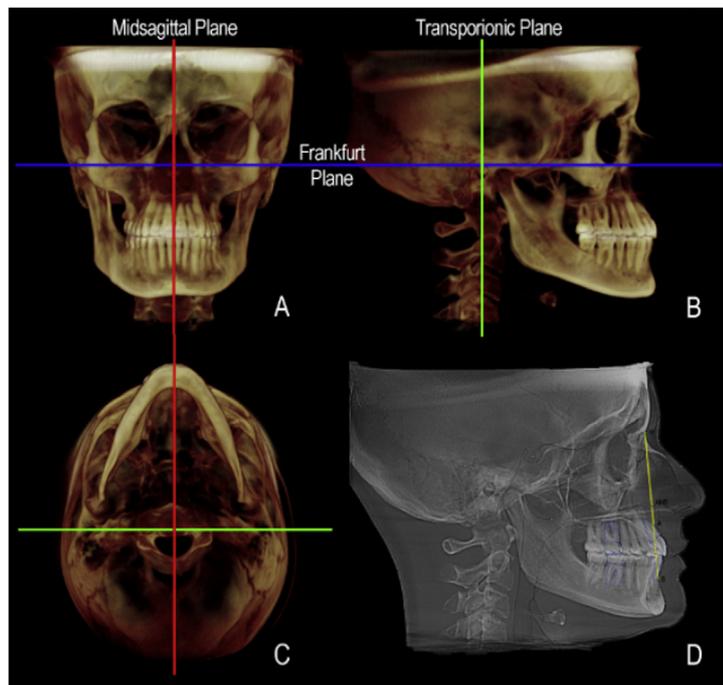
Standardization of the CBCT scan before angular measurements: (A) alignment of the Frankfurt horizontal and midsagittal planes on the frontal view; (B) alignment of the Frankfurt horizontal and transporionic planes on the right view of the three-dimensional reconstruction; (C) alignment of the midsagittal and transporionic planes on the bottom view; (D) A-point–nasion–B-point angle (ANB) measurements analyzed in Dolphin software.
